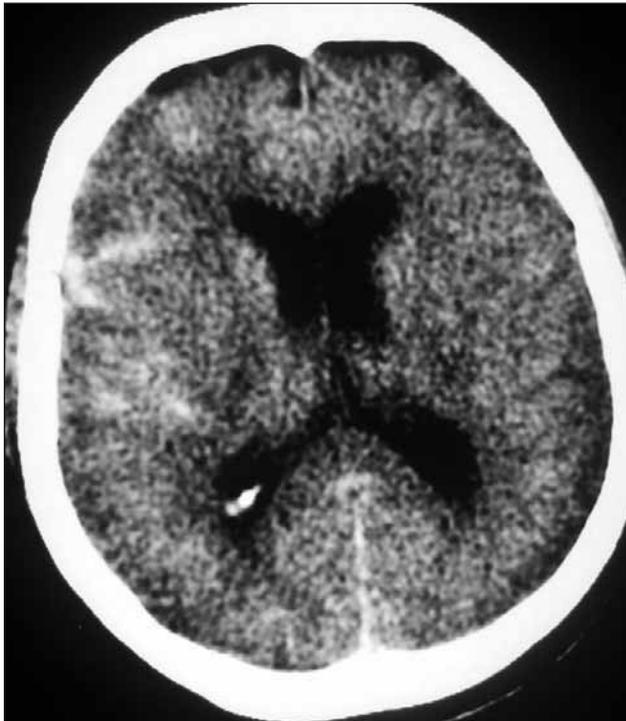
Axial CT scan taken during admission showing SAH in the right Sylvian fissure.
